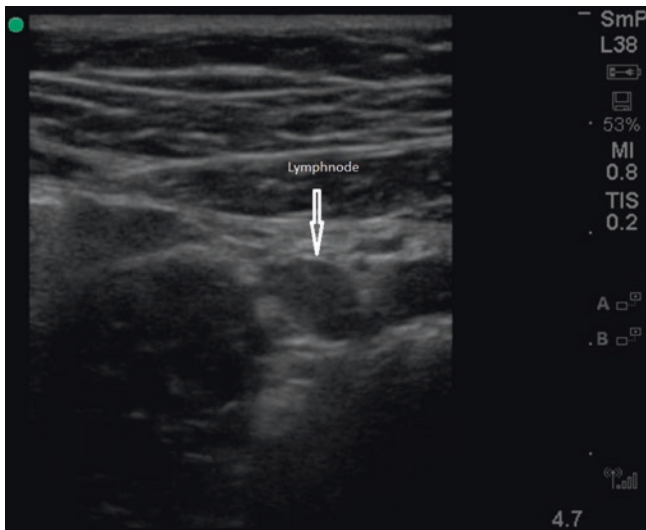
Enlarged mesenteric lymph nodes can mimic appendicitis. The diagnosis of appendicitis may not be excluded even though mesenteric lymph nodes are present if the index of suspicion is high for appendicitis. A color Doppler may assist to distinguish between a vessel and an abdominal lymph node
